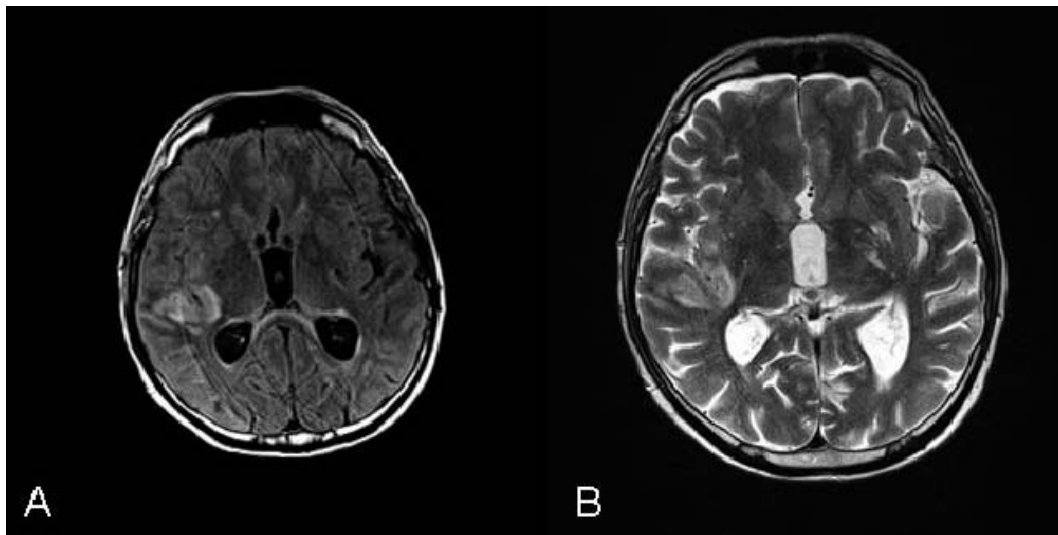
Cranial magnetic resonance imaging. (1A) The cranial magnetic resonance imaging revealed the presence of numerous small enhancing lesions in both cerebral and cerebellar hemispheres. (2B) T2-weighted sequences TSE documented meningeal thickening, caused from diffuse leptomeningeal inflammation.
